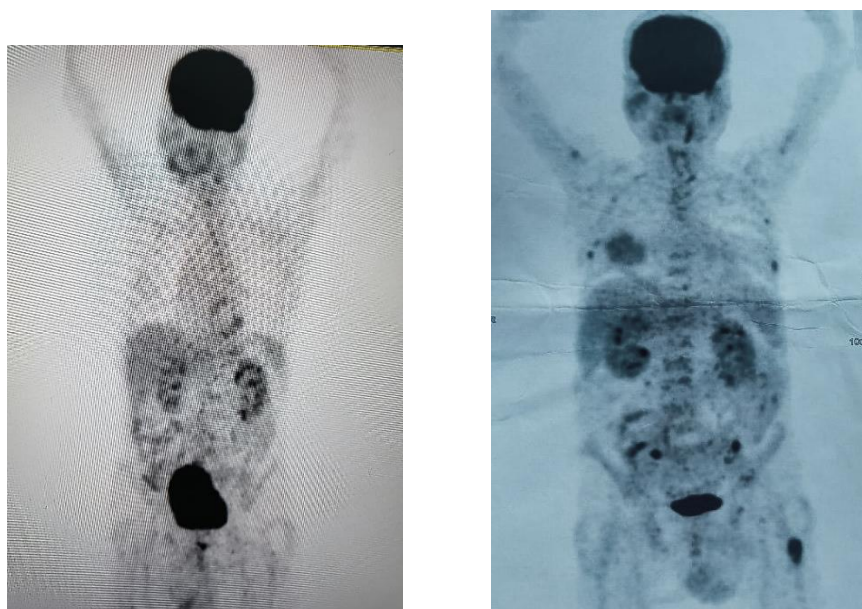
The maximum intensity projection image of PET/CT performed after the 3rd cycle of chemotherapy reveals a favorable response to treatment, demonstrating complete metabolic regression in the costal, humeral, pelvic, and femoral bone locations
